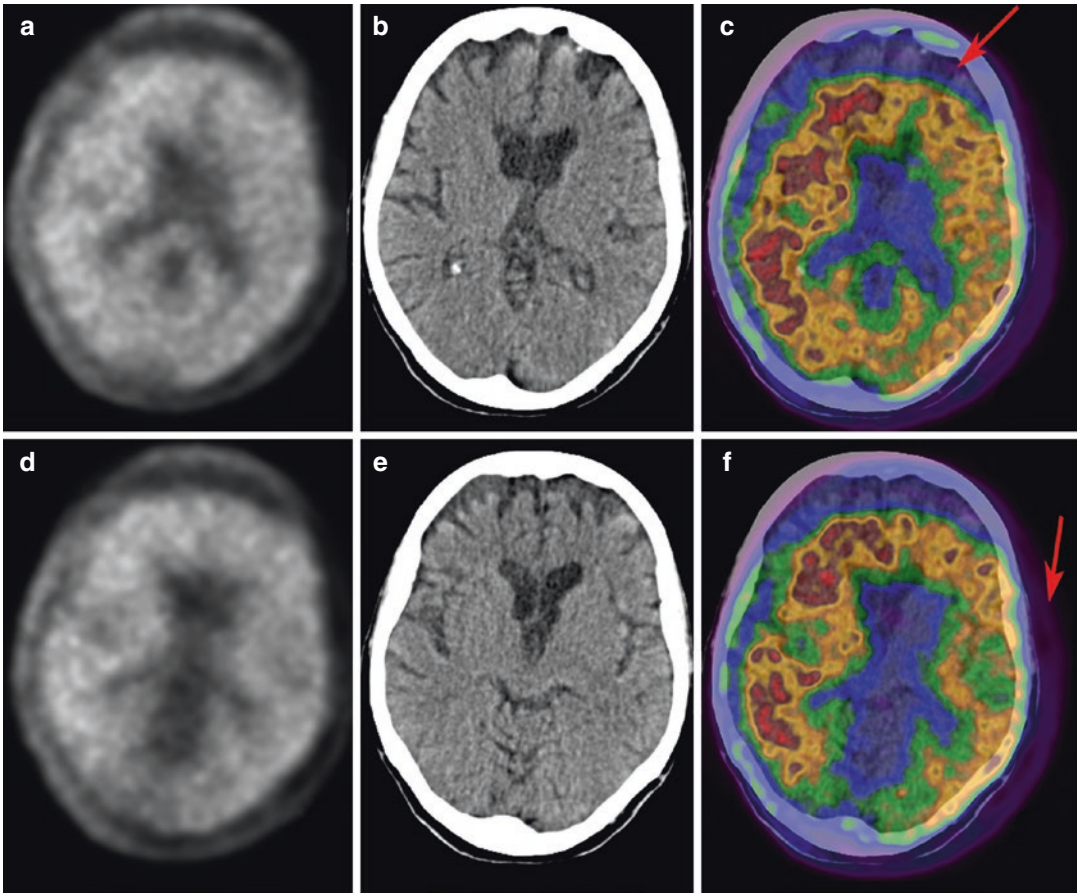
In a patient with Alzheimer's disease, examined with ^{18}F -florbetaben PET/CT, an example of motion artifacts due to the head rotation between PET (a, d) and CT (b, e) scans, with abnormal PET/CT fusion imaging (c, f, arrows)
